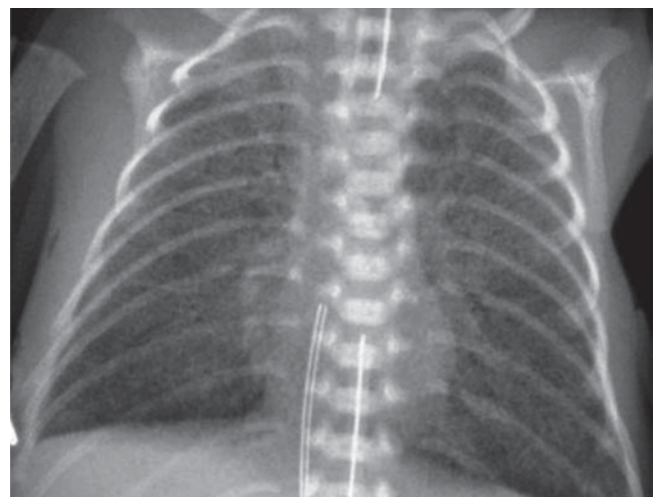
A–P chest radiograph of premature newborn shows a bilateral and symmetrical diffuse ground glass lungs with a hyperinflated thorax (because of the intubation). Without intubation, the thorax typically has a low volume. In some patients, air-bronchogram can be seen. The patient has venous and arterial umbilical catheters
